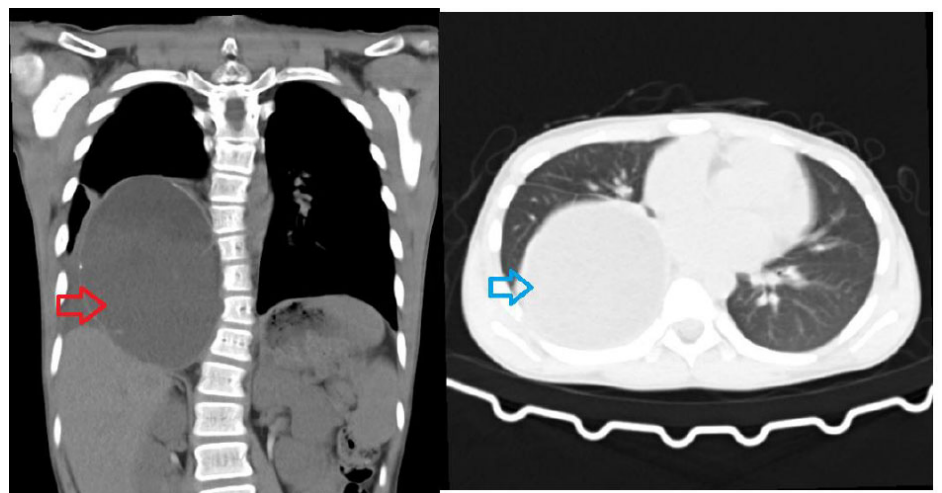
Pre-operative computed tomography scan: coronal view of the mass without contrast-enhanced (red arrow) and axial view of the mass with contrast-enhanced (blue arrow).
